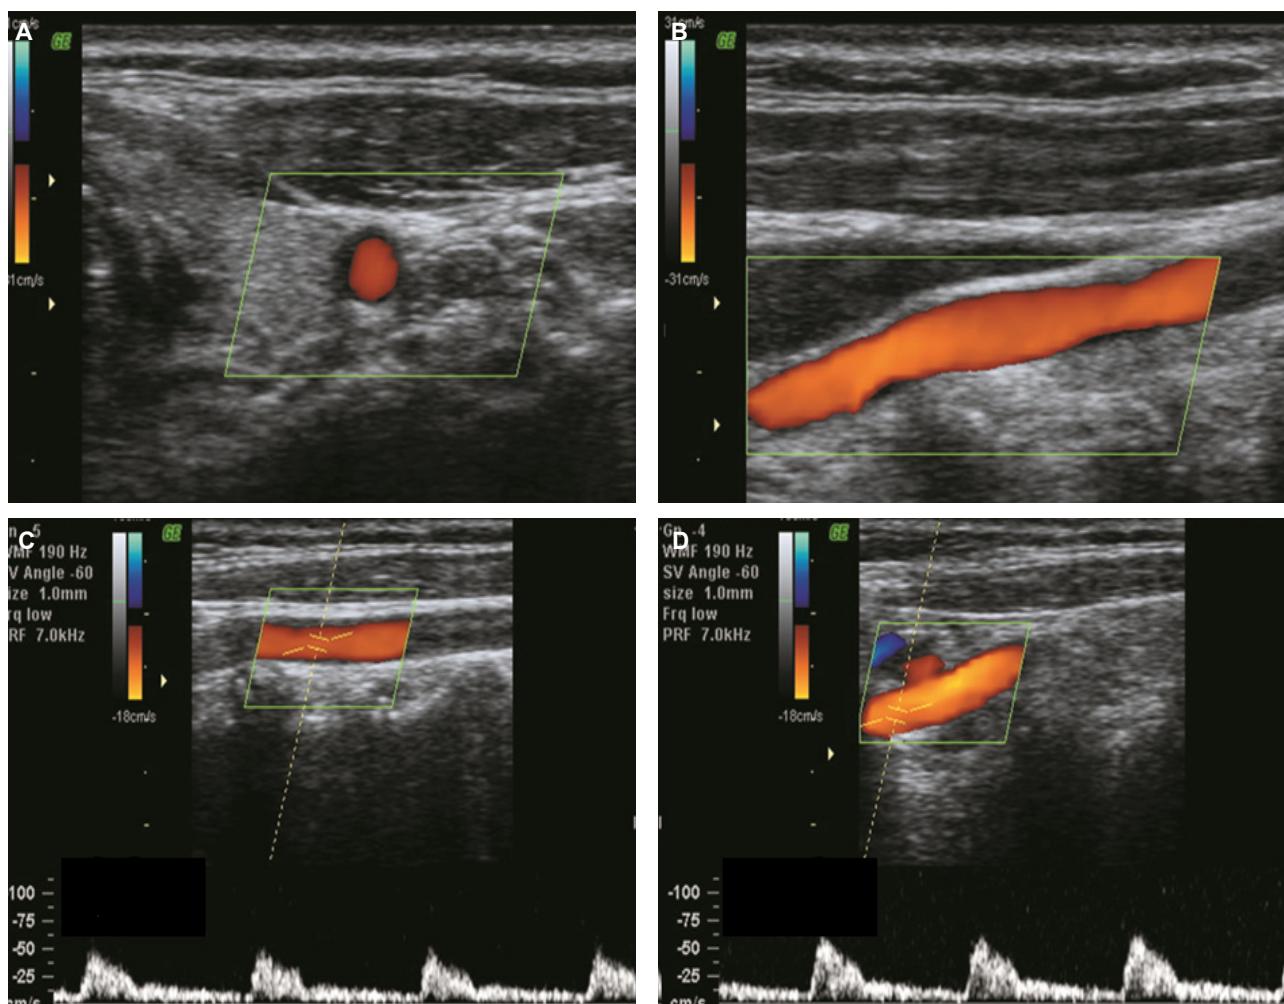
(A) Color-coded duplex sonography shows the absence of the left internal carotid artery (ICA). (B) The common carotid artery (CCA) of diminished caliber terminates in the external carotid artery (ECA). (C) The CCA demonstrates high-resistance spectral waveforms with sharp systolic peaks and little diastolic flow. (D) The left ECA waveform demonstrates high-resistance characteristics and is indistinguishable from the CCA waveform.
